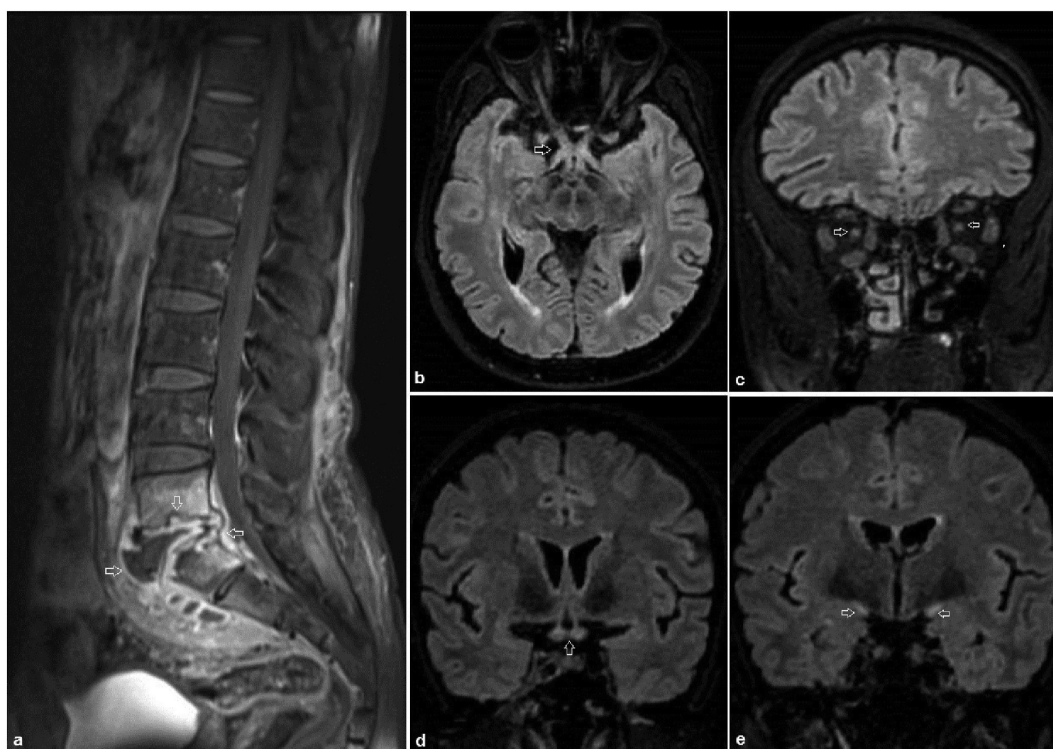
(a) Post-contrast Sagittal T1 fat-saturated image of the Lumbosacral spine showing spondylodiscitis involving the L5 and S1 vertebrae with prevertebral and anterior epidural soft tissue component (arrows) - s/o Tubercular etiology, (b) Axial 3D FLAIR image showing hyperintensity in the optic chiasm and proximal portion of both the optic tracts (arrows), (c) Coronal 3D FLAIR image showing normal signal intensity of both the optic nerves (arrows), (d and e) Coronal 3D FLAIR image revealing hyperintense signal intensity of the optic chiasm (d) and bilateral optic tracts (e) (arrows).
